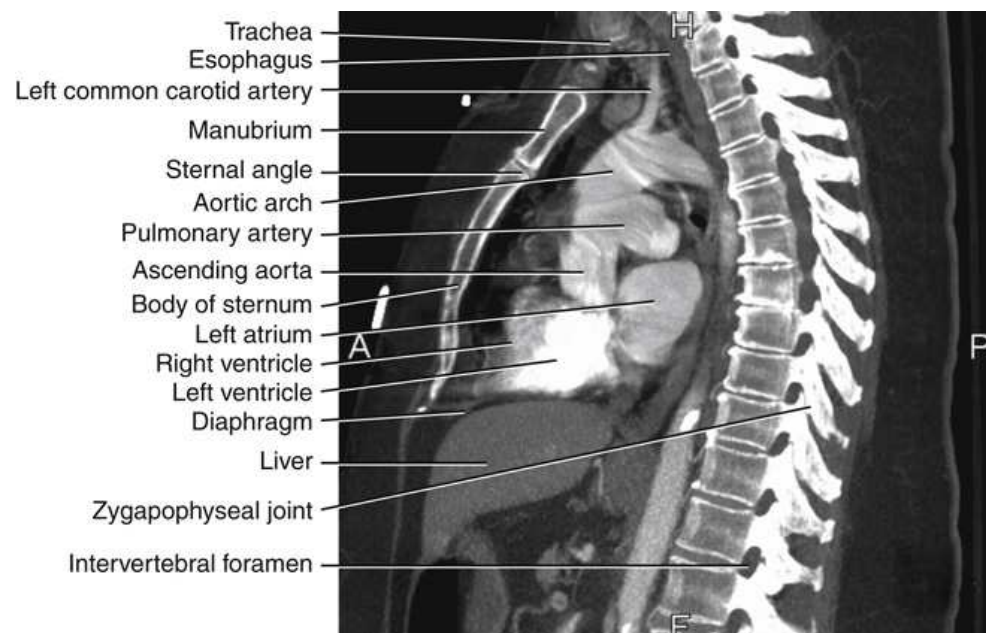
Sagittal CT image of thorax corresponding to level A in Fig. 24.39.
